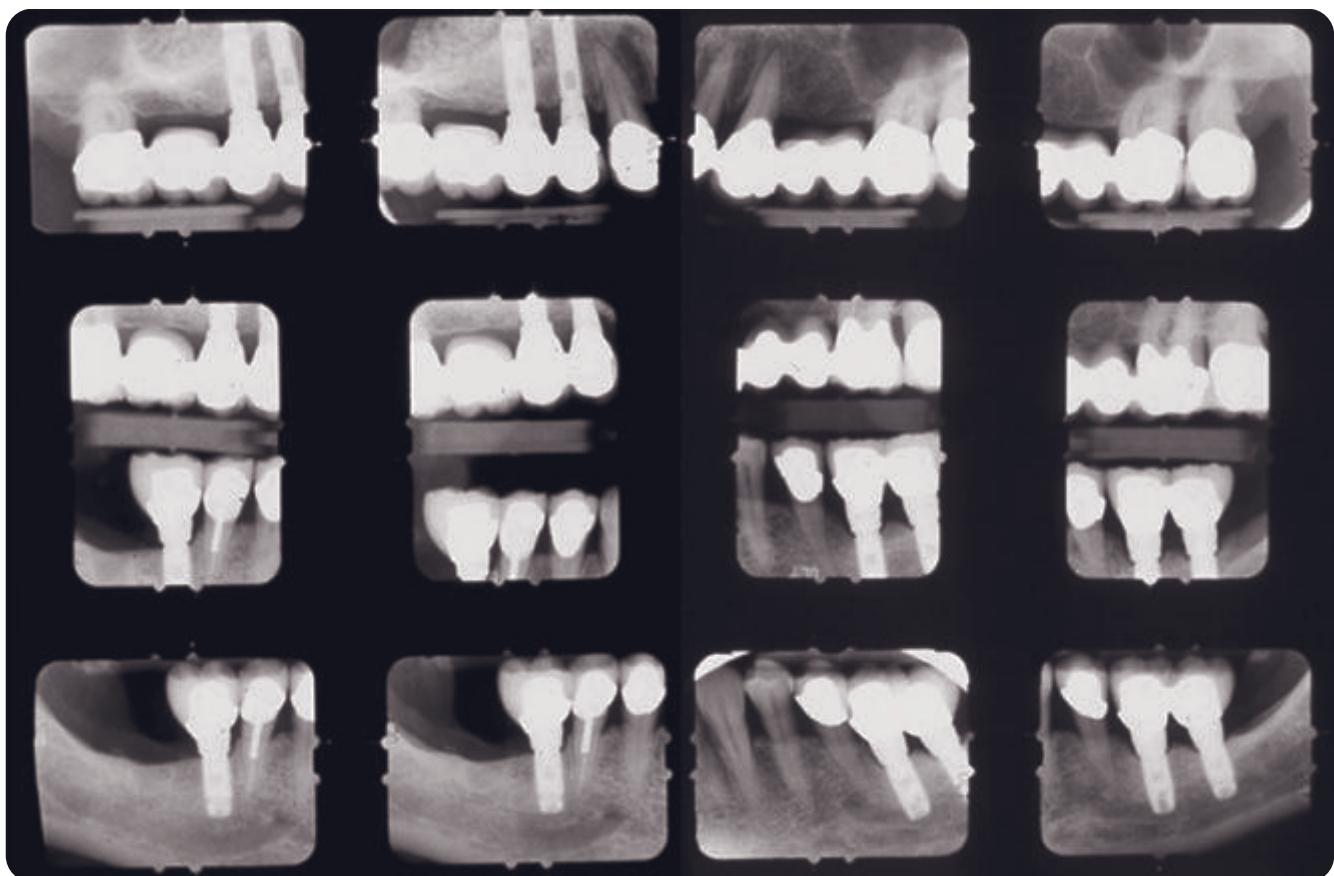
Posttreatment periapicals.
